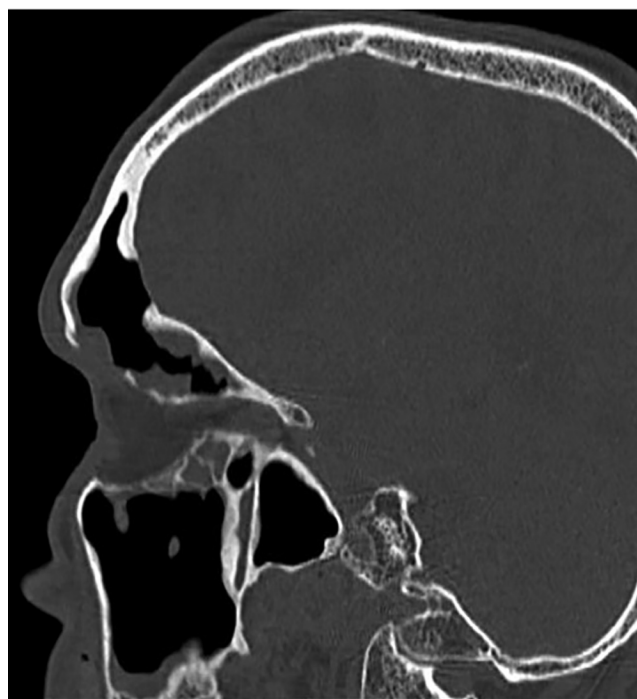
Postchemotherapy computed tomography of the sinuses demonstrates near resolution of the left frontal sinus mass; areas of supraorbital and posterior table dehiscence are evident.
